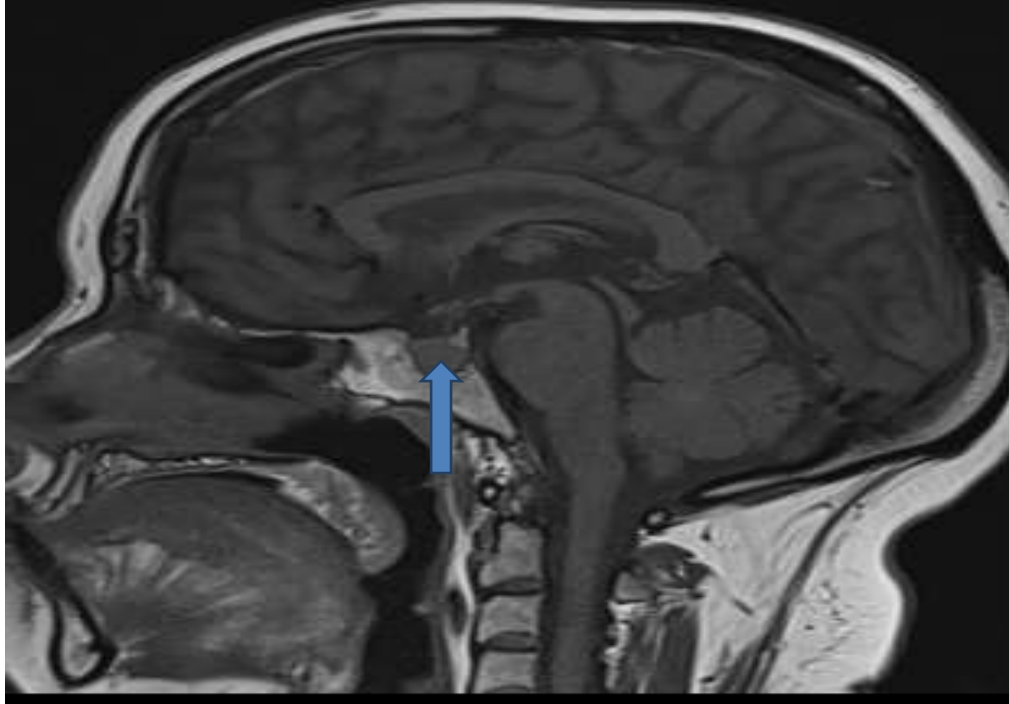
Follow-up sagittal section MRI showing tumor residue.
